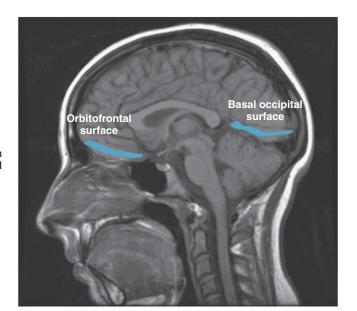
The basal frontal and occipital lobes are highlighted on a sagittal MRI scan. The gyri of the mesial surface of the cerebral hemisphere (frontal, parietal, and occipital) are also visible.
